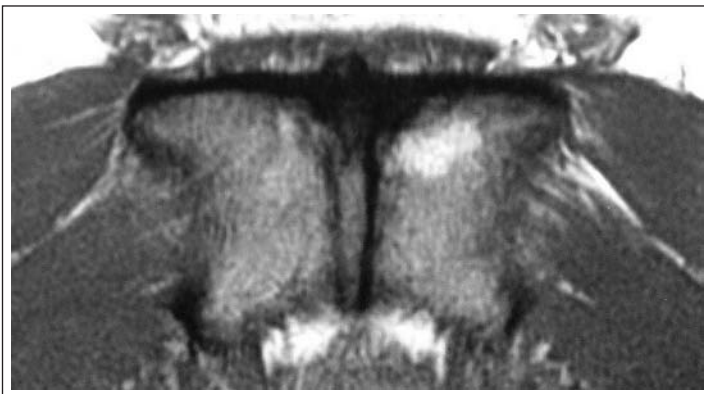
Axial T2 MRI scan (from below) showing tendon changes primarily in the deep surface of the left adductor longus tendon attachment, with additional changes in the adductor brevis tendon attachment and left pubic bone marrow oedema.
